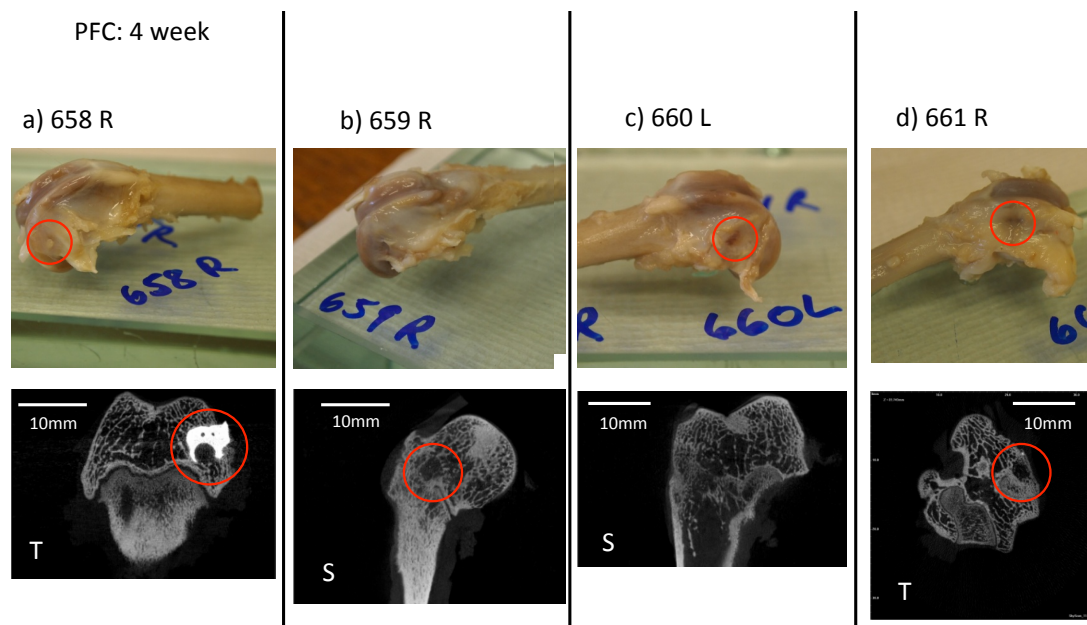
PPGDMA Micro CT images after four weeks in-vivo. Material only visible in 658R defect visible in 659R and 661R. Defect sites marked with red circles. Neither material nor defect visible in 660L. Images marked with T and S are in the transverse and sagittal planes respectively.
